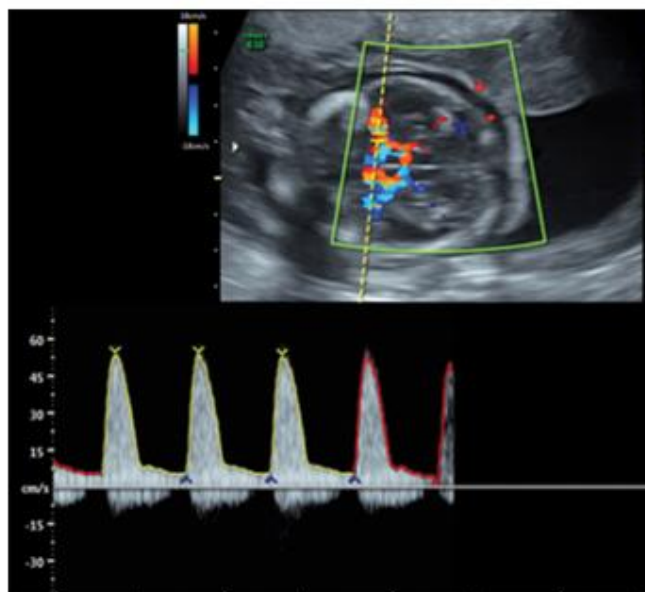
showing Color Doppler sonography spectrum of MCA in second trimester demonstrating normal waveforms
